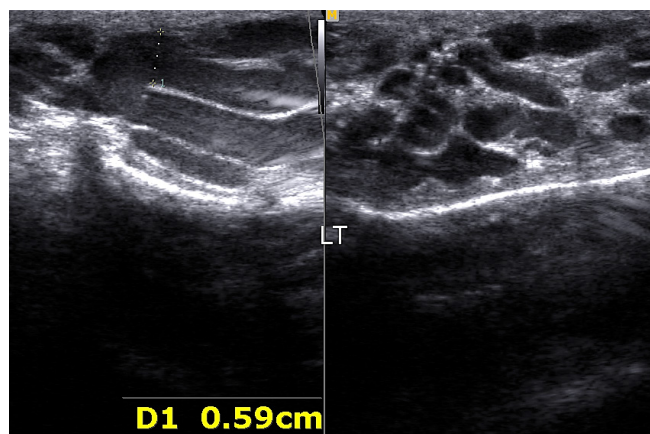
B-mode ultrasound demonstrating markedly dilated extratesticular varicoceles, with venous diameters measuring up to 5.9 mm
